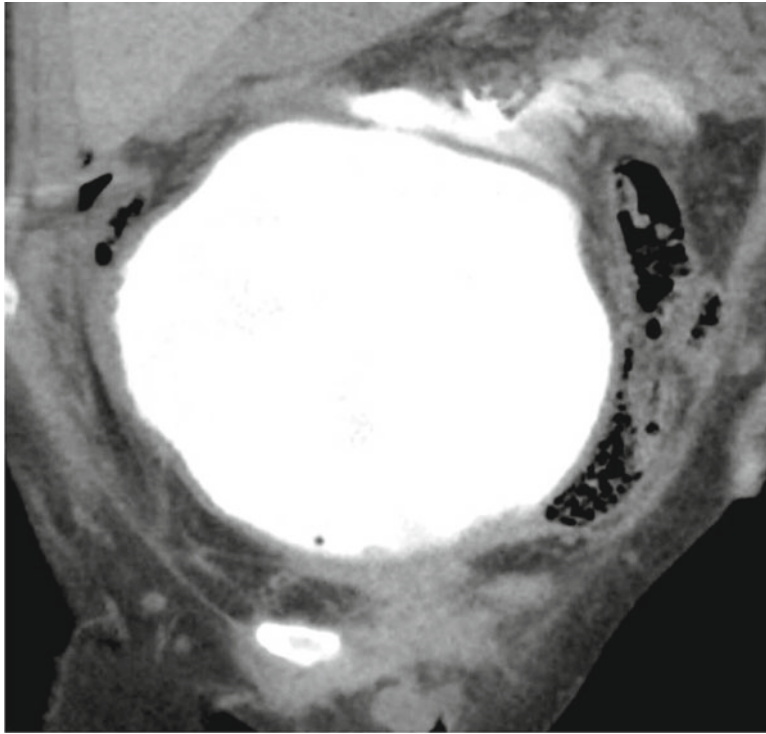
Contrast extravasation on CT cystogram indicating bladder rupture in a patient with spina bifida and history of colostomy
